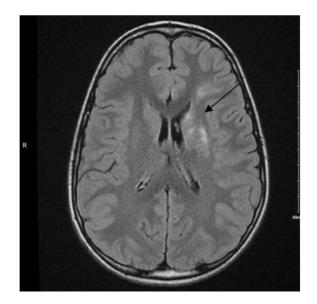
Brain MRI Newly seen focal left frontal periventricular white matter acute infarct (black arrow). Partial evolution of the prior multifocal left frontal and basal ganglia infarcts. - Marginal worsening of the left proximal M1 stenosis with still seen enhancement suggesting vasculitis. - The left subarachnoid ICA and A1 stenosis did not change. The right M1 irregularity is less apparent now.
